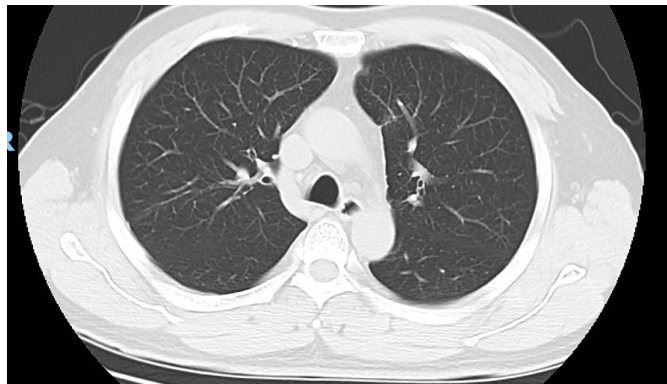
Chest CT re-examined on August 30, 2020, showed a tiny nodule approximately 1 mm in diameter in the anterior segment of the right upper lobe and lateral basal segment of the lower lobe, similar to previous imaging. A small fiber-like shadow was observed in the left upper lung, similar to earlier findings. A few cord-like structures were visible under the pleura of the left lower lobe. No pleural effusion was detected in either thoracic cavity. On the right side of the upper mediastinal trachea, a capsular bright shadow was noted, similar to previous imaging.
